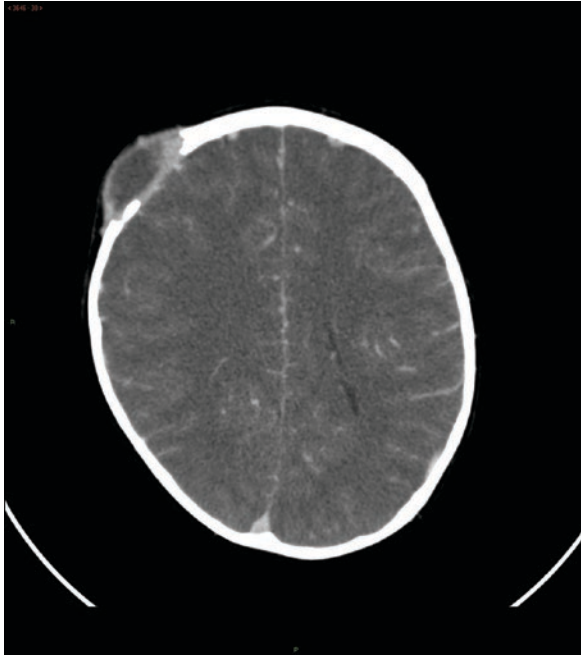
Axial contrast-enhanced CT image demonstrates an extracranial soft-tissue mass in association with an LCH lytic bone lesion
